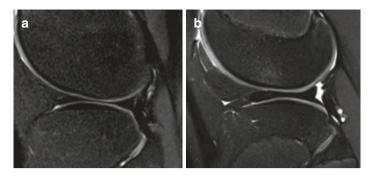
MRI classification for meniscal tears. (Image reprinted [6])
